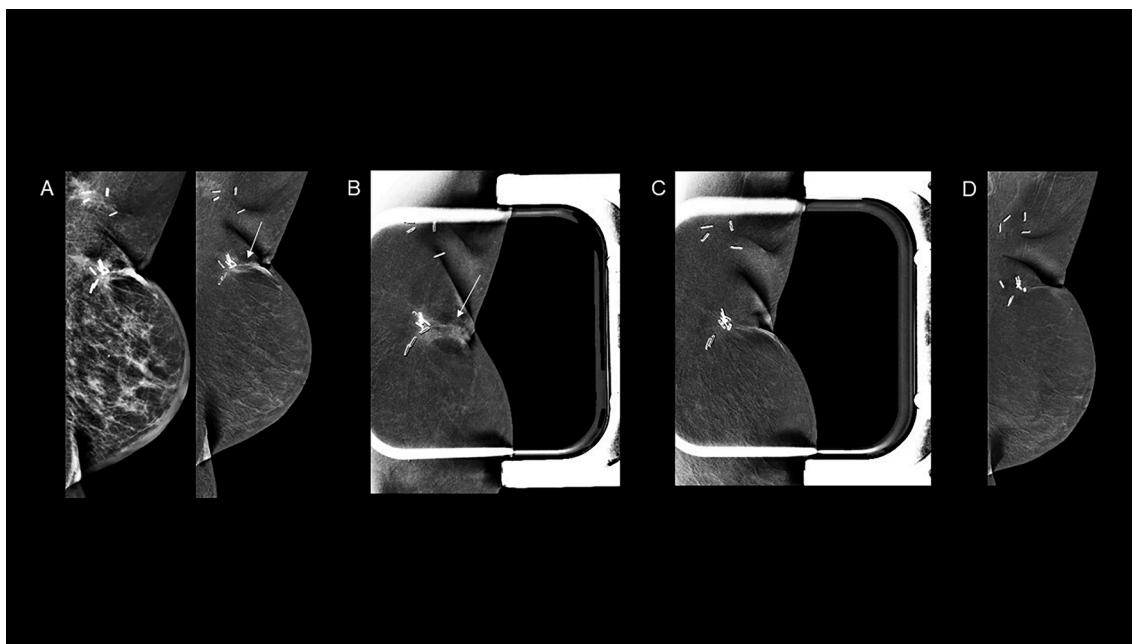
64-year-old with history of recent left lumpectomy and radiation for breast cancer. The first post-treatment contrast-enhanced mammography shows an enhancing asymmetry at the lumpectomy site extending to the skin on low-energy and recombined mediolateral oblique views (A), including spot compression recombined view (B). As no corresponding abnormality was identified on targeted ultrasound, enhancement was probably benign post-treatment change. Enhancement resolved on follow-up contrast-enhanced mammography performed at six months (C) and at one year (D), confirming the benign etiology.
